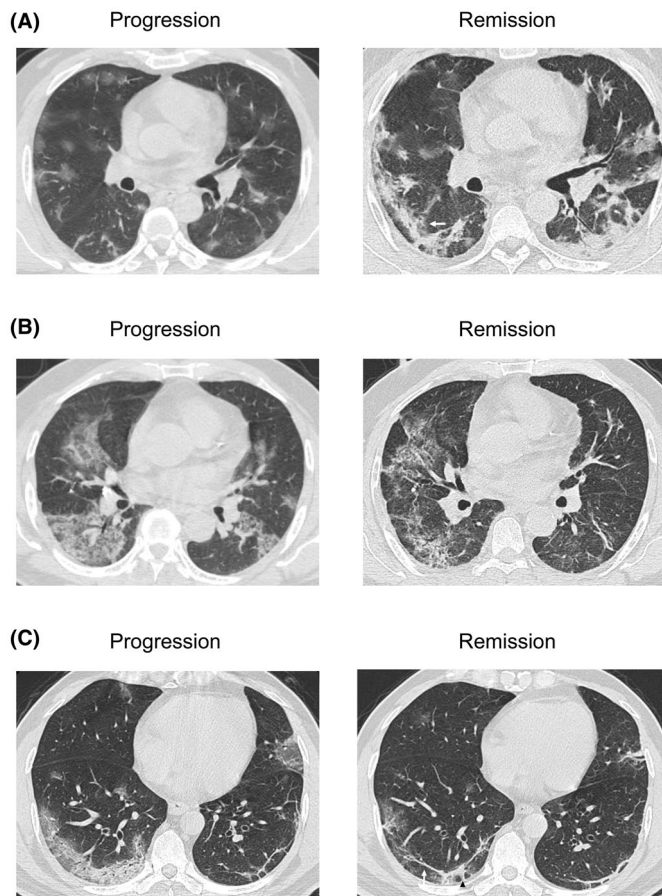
Typical chest CT images. (A) A 43-year-old male patient with severe COVID-19. Left: Scan on the third day after onset of symptoms (progression). Multiple patchy ground-glass opacities (GGOs) were observed. Right: Scan on the 13th day after onset of symptoms (remission). Lesion volume was reduced, consolidation was significantly increased, and the linear consolidation sign parallel to the pleura appeared in the subpleural area (white arrow). (B) A 67-year-old male with severe COVID-19. Left: Scan on the seventh day after onset of symptoms. Multiple patchy GGOs and some crazy-paving signs can be seen. Right: Scan on the 25th day after onset of symptoms (remission). Lesions were significantly improved and absorbed, thin sheets of GGO and cable signs can be observed. (C) A 58-year-old male patient with ordinary-type COVID-19. Left: Scan on the eighth day after onset of symptoms (progression). Multiple patchy GGO shadows can be observed, ground glass with consolidation and stripe shadows in multiple areas. Right: Scan on the 15th day after onset of symptoms (remission). Lesion size was reduced, and consolidation and large cable signs can be seen (some cables parallel to the pleura, as indicated by the white arrow and some cables bridged to the pleura, as indicated by black arrow heads)
